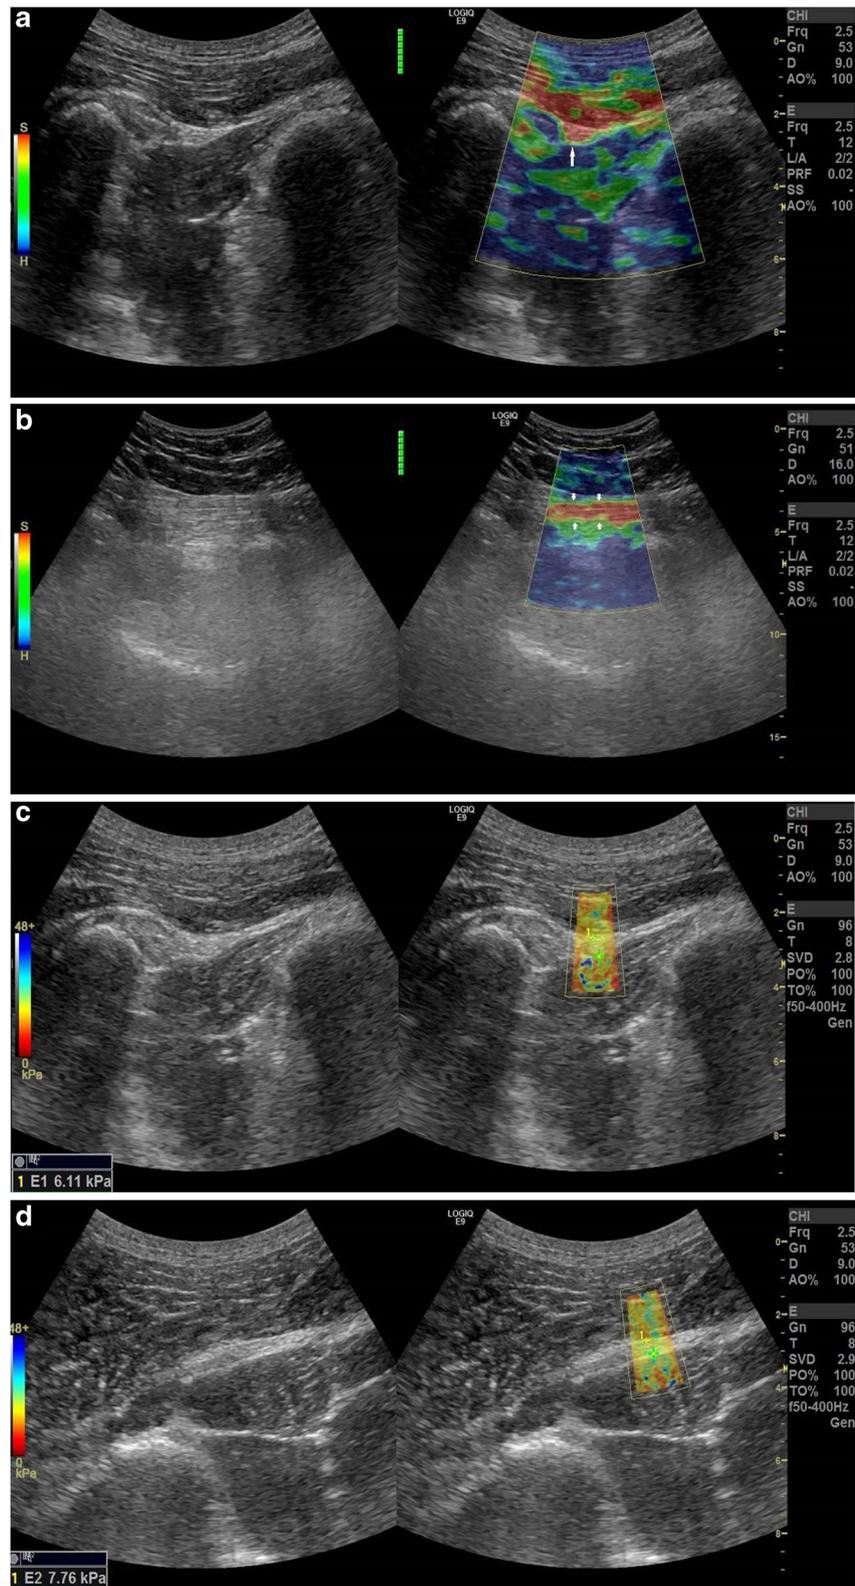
A 22-year-old female healthy subjects. Magnetic resonance imaging designates the right and left neural foramens as normal. The left sciatic nerve (*white arrows*) shows pattern 3a on the axial (a) and longitudinal
